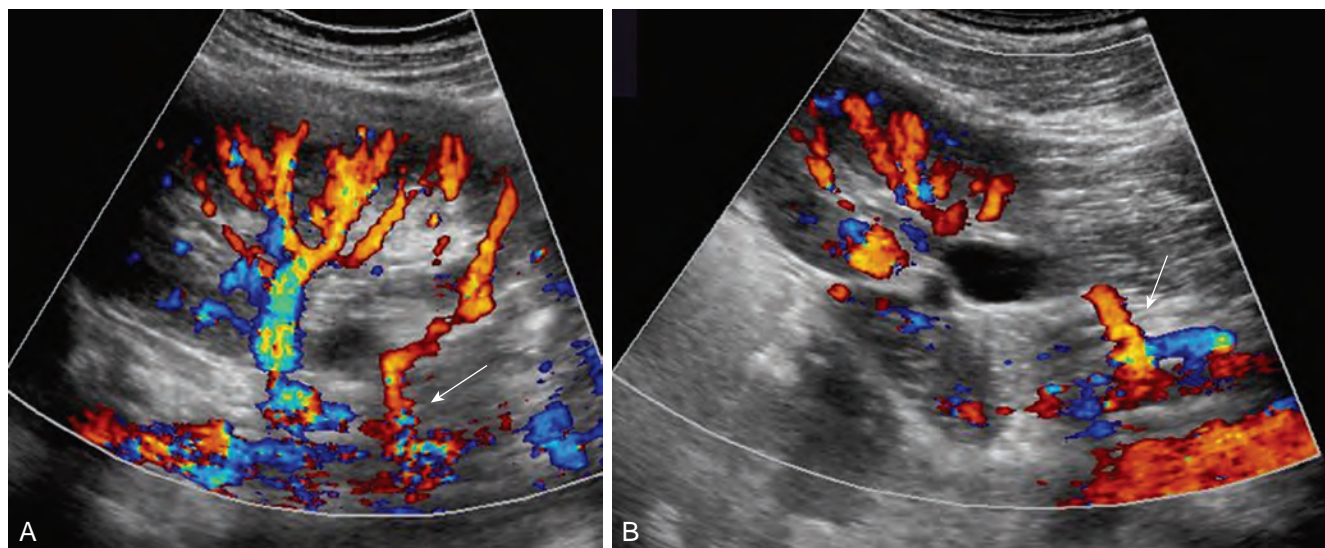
Nine-year-old girl with intermittent left flank pain, nausea, and vomiting. A, Color Doppler ultrasound study shows normal left renal artery and lower pole accessory vessel (arrow). B, Oblique sagittal view shows left lower pole accessory vessel (arrow) supplying the lower pole of the kidney, causing intermittent left ureteropelvic junction obstruction.
